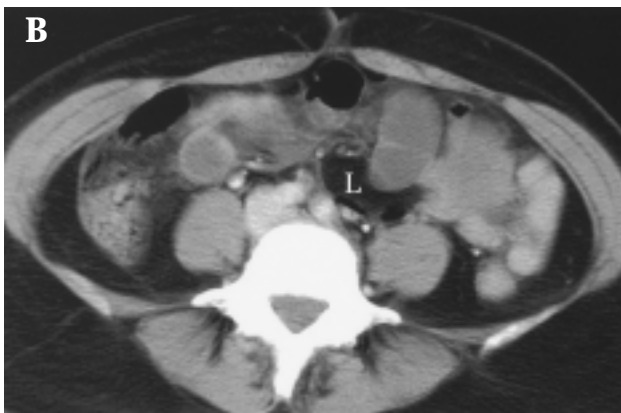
(A) Contrast-enhanced computed tomography showing a whirl-shaped appearance of mesentery (arrow) at the lower left abdomen and dilatation of small bowel at the level of distal ileum. (B) A fatty component mass-like lesion (L) was found 10 mm above the dilated small bowel loops.
